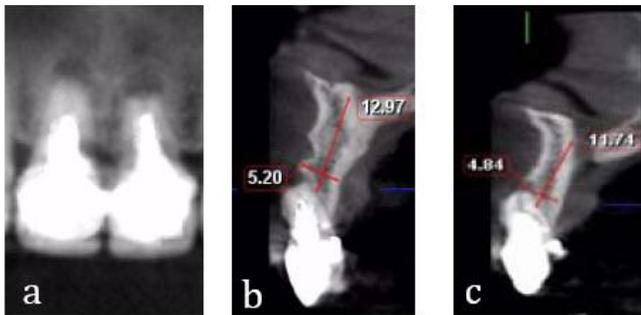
(a)CBCT images of bilateral central incisors in maxilla; (b) sagittal image of right central incisors in maxilla; (c) sagittal image of left central incisors in maxilla.
